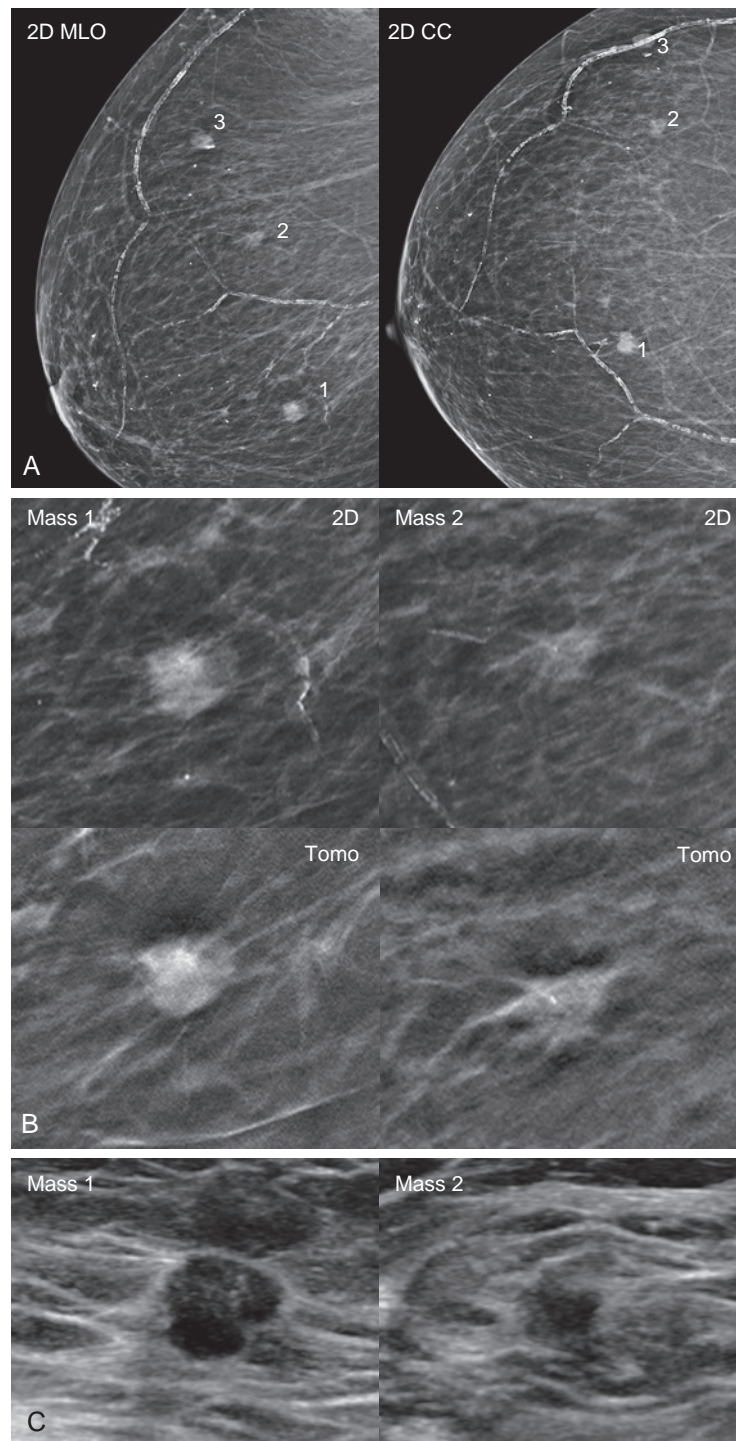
Multicentric infiltrating ductal cancer in fatty breast tissue better seen with tomosynthesis. (A) 2D mammogram in a 79-year-old woman shows three distinct masses in the right breast (*numbered*). Mass 3 is associated with a biopsy marker clip and is benign. (B) Comparison of close-up 2D and tomosynthesis MLO views show the subtle spiculated margins associated with masses 1 and 2 are much more obvious on tomosynthesis. In this case additional spot compression views were unnecessary. (C) Targeted ultrasound reveals corresponding suspicious solid hypoechoic masses. Mass 1 is oval with angular and indistinct margins, whereas mass 2 is irregularly shaped with indistinct margins. Ultrasound-guided core needle biopsy at both sites yielded infiltrating ductal carcinoma, grade 2, ER/PR+, Her2-, Ki67 = 5%. The patient underwent right partial mastectomy.
